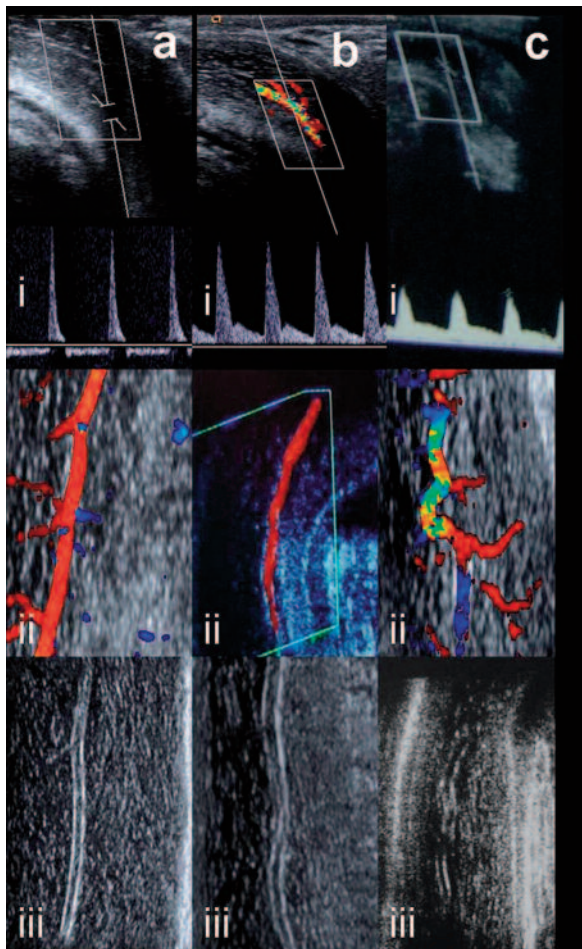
Images from different subjects. (a) Normal, (b) with venous insufficiency, (c) with arterial insufficiency. In these three separate groups: spectral patterns (i), color Doppler images (ii) and gray scale images obtained parallel to the longitudinal axis of the related cavernous arteries are shown.
